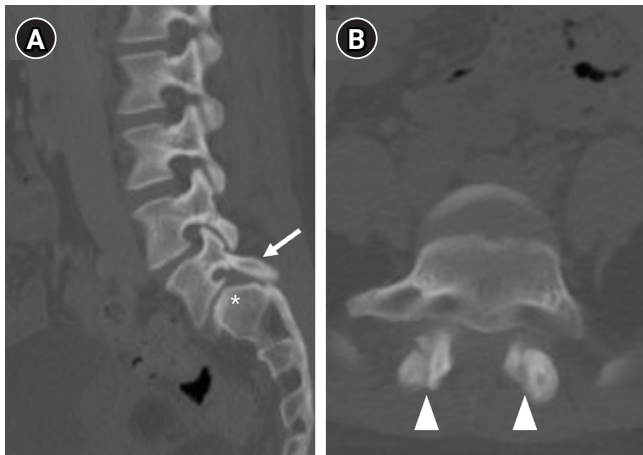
Computed tomography demonstrating characteristic dysplastic features at the L5–S1 level. (A) Sagittal computed tomography (CT) image demonstrating elongation of the L5 pars interarticularis (arrow) and sacral dome deficiency (asterisk). (B) Axial CT image demonstrating vertically oriented L5–S1 facet joints (arrowheads).
